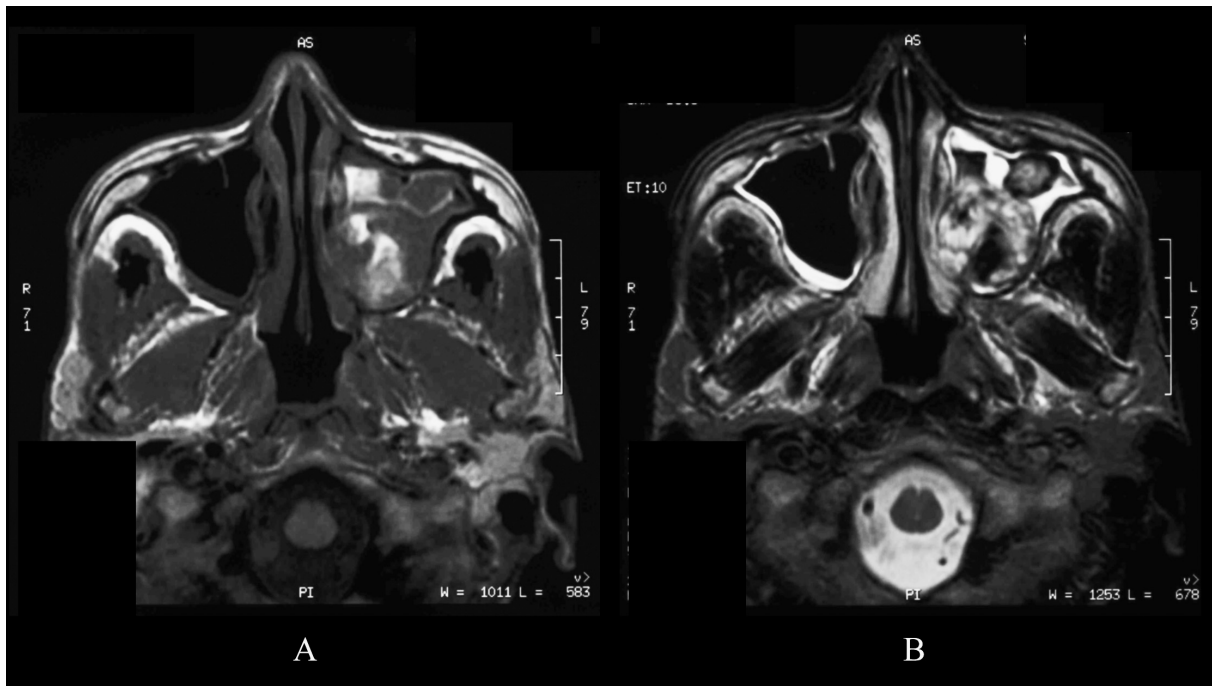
MRI of case 2. The lesion shows intermingled low/intermediate/high signal intensity on both T1- (A) and T2- (B) weighted MRI.
